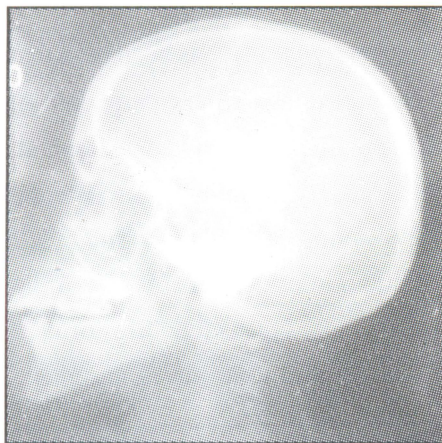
Photograph showing radiograph revealing small skull.
